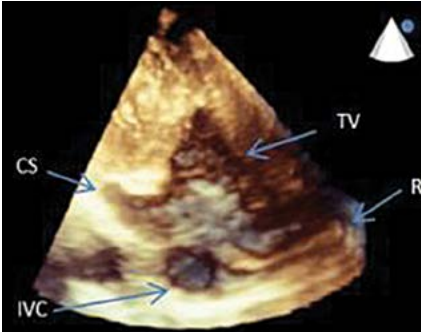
3D echocardiographic image of the right ventricular inflow tract (R – ridge)
